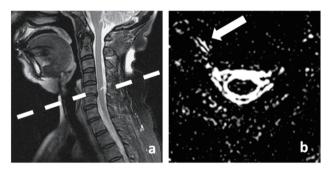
Sagittal view of T2-weighted spine MRI (a) and transverse view of heavily T2-weighted MR myelography at level C5-6 (b). Dashed line in (a) indicates the level of (b), and arrow in (b) indicates CSF accumulation along the right intervertebral foramen to the right paraspinal region, showing the site of CSF leakage.
